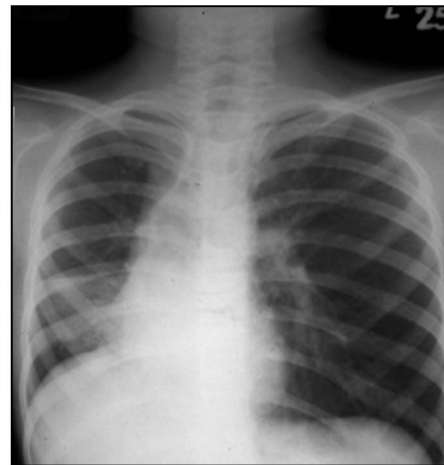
Repeat Chest Xray showing gross mediastinal shift to the right.
